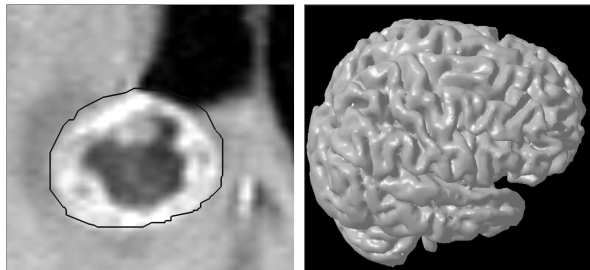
Left: In-plane tumour contour on axial MRI. Right: 3D visualization of the cortex.
